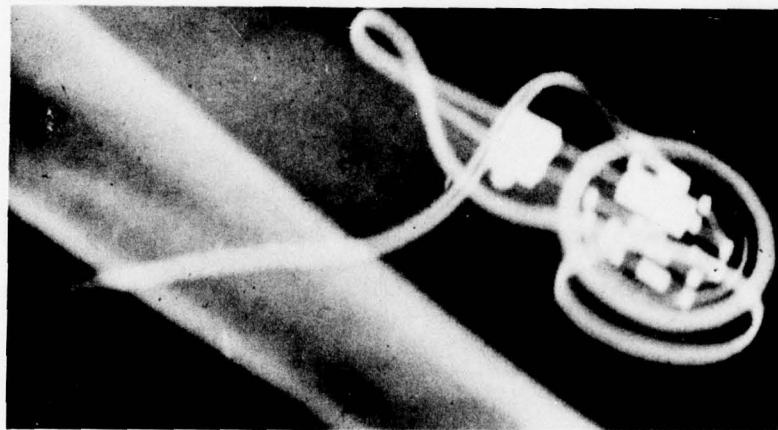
X-ray of implanted NMA.
